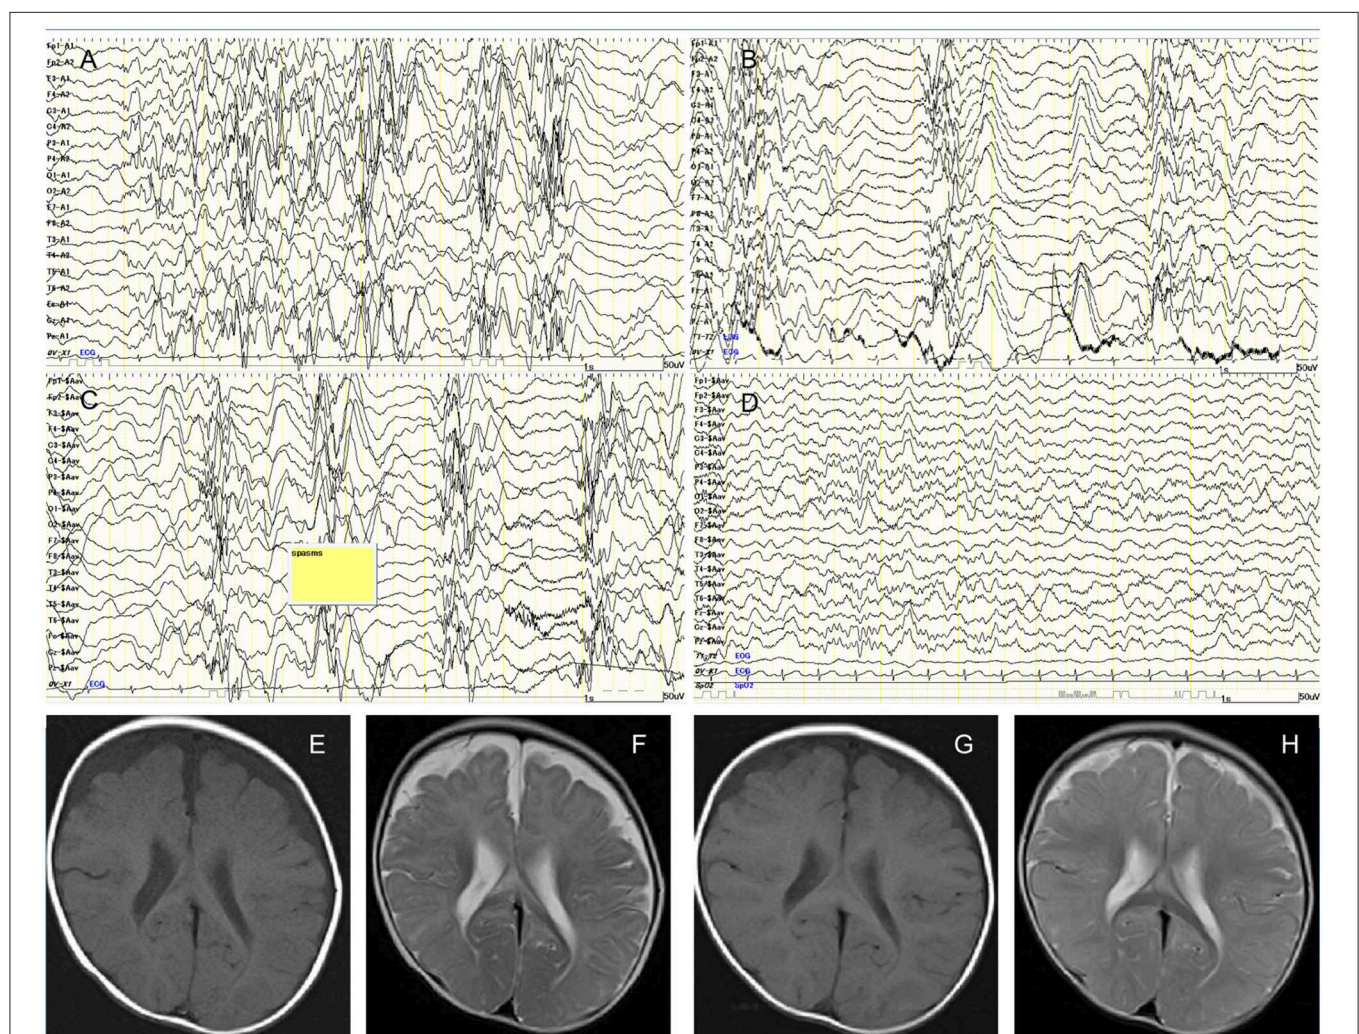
(A) Interictal awake electroencephalography at 7 months showing the characteristic random high-voltage slow waves with spikes and polyspikes activity. (B) Fragmentation of the hypsarrhythmic activity is noticed during sleep recording. (C) Ictal EEG recording showing a cluster of epileptic spasms with high amplitude slow wave at each spasm. (D) Sleep recording showed normalization of background EEG observed 2 months after treatment. (E) Axial T1-weighted image. (F) Axial T2-weighted image of cranial MRI before initiation of adrenocorticotrophic hormone therapy at 7 months of age showing cerebral atrophy with frontal predominance and delay in myelination. Follow-up imaging after vitamin B12 supplementation at 14 months of age documenting improved delayed myelination and cerebral atrophy. (G) Axial T1-weighted image. (H) Axial T2-weighted image.
